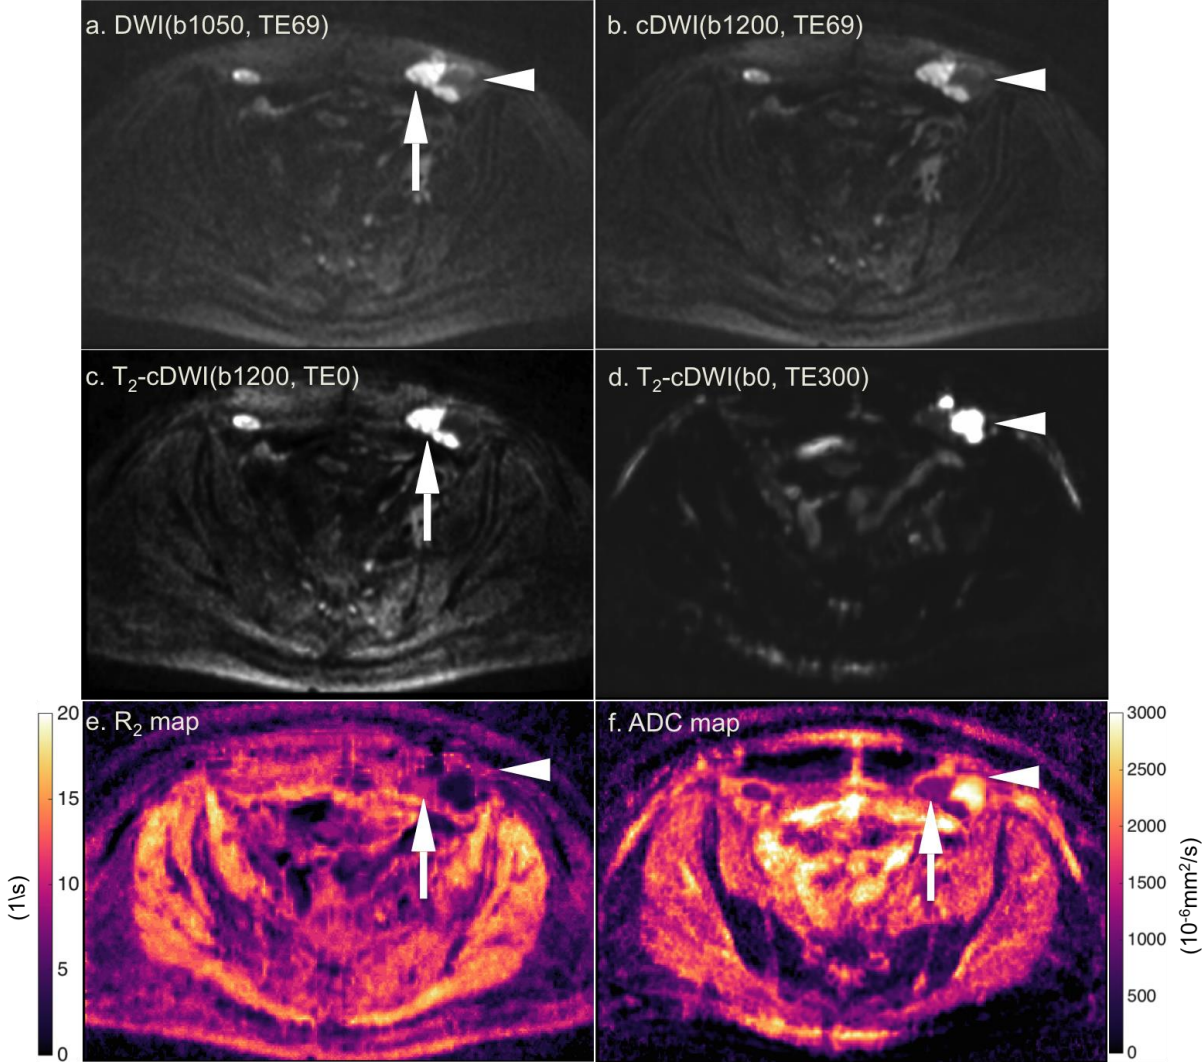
Axial DW MR images of a 59-year-old woman with ovarian cancer (a) acquired using b-values of 1050 s/mm<sup>2</sup> at TE of 69 ms, and (b) computed DWI (b-value of 1200 s/mm<sup>2</sup>, TE of 69 ms), and (c) T<sub>2</sub>-adjusted computed DWI (b-value of 1200 s/mm<sup>2</sup>, TE of 0 ms). e) R<sub>2</sub> map and (f) ADC map generated from all acquired images. Arrow: ovary
